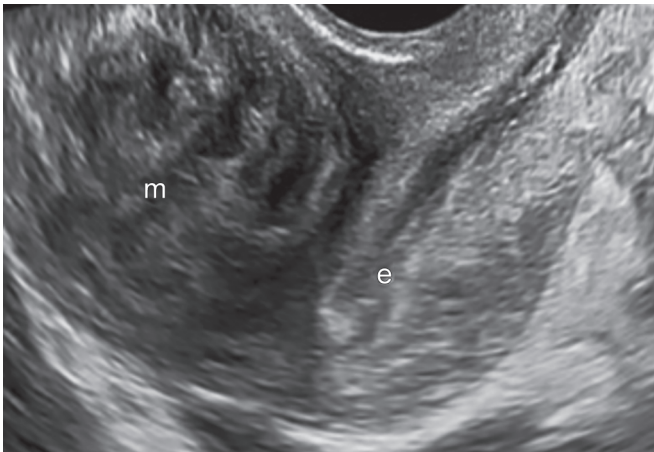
Echogenicity of the leiomyoma: (A) Uniform roundish lesion and is echogenic as myometrium on 2D and 3D ultrasound—3D—leiomyoma (yellow arrow), endometrium (green arrow), myometrium (white arrow); (B) 2D ultrasound
